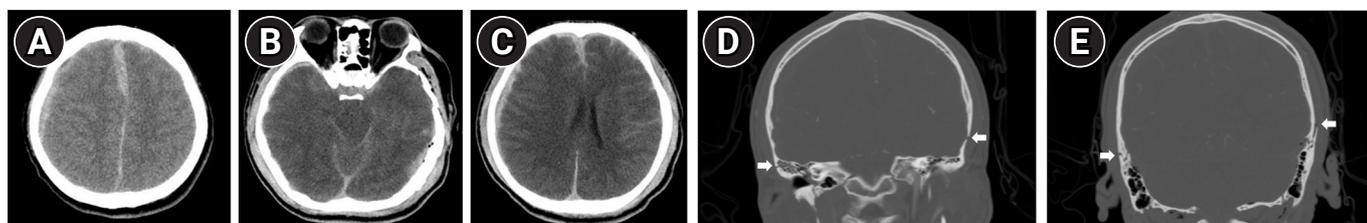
Initial brain computed tomography (CT) of the patient. Axial view of brain CT (A-C) showed traumatic epidural hemorrhage in the right frontotemporal lobe and left occipital lobe, and acute subarachnoid hemorrhage. Coronal view of facial bone CT (D, E) demonstrated multiple skull base fractures on both sides (white arrows).
